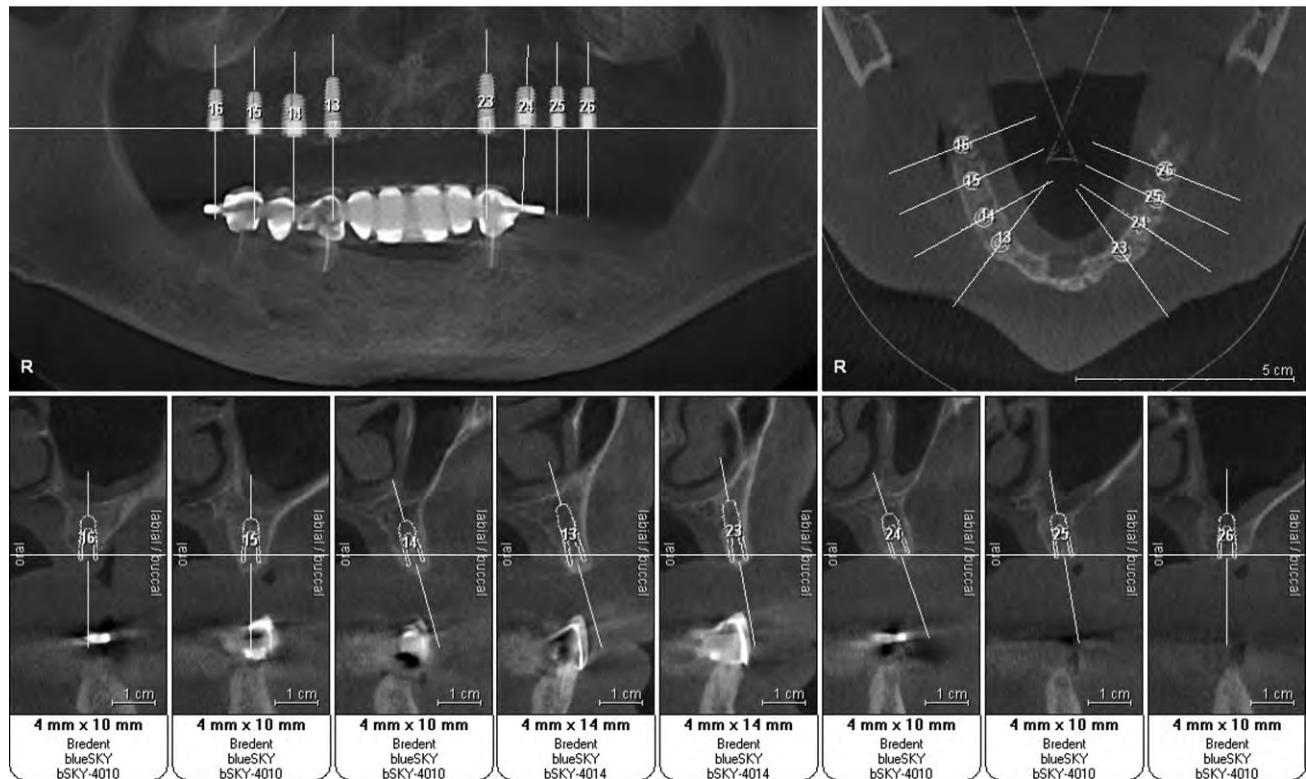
Preoperative implant planning. Assessment of jawbone density and optimal implant position using computed tomography imaging.
